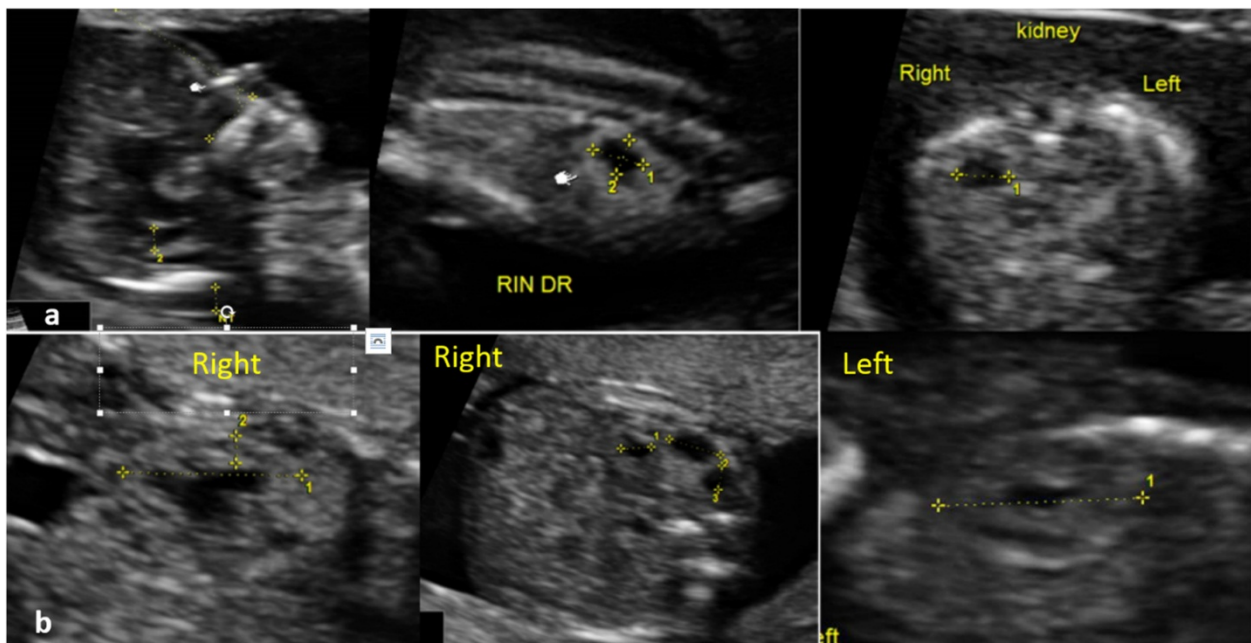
Case 3, ultrasound features at 12+4 gestational weeks (first row) and at 16+5 gestational weeks (second row)
